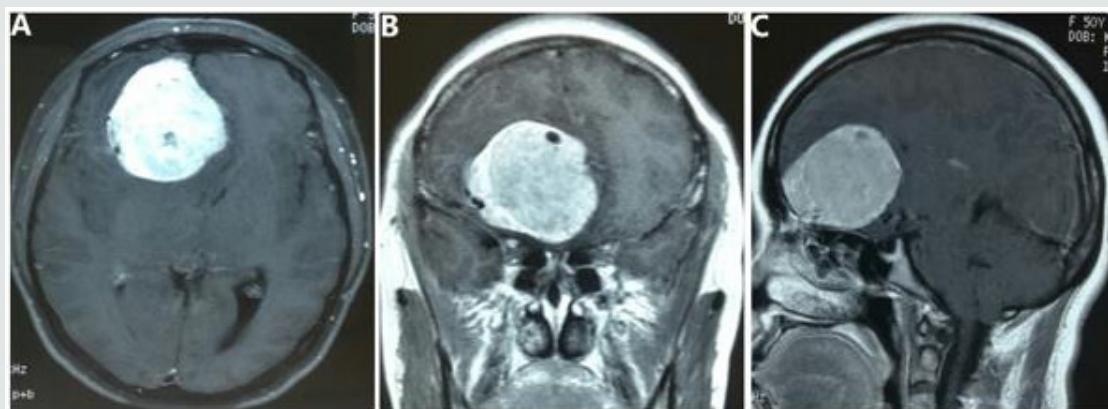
Preoperative MR images.
